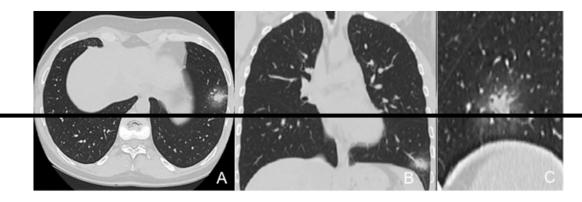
Axial-2D (A), coronal-2D (B) and sagittal-2D (C) chest CT images show a left lower lobe single rounded consolidation surrounded by well-defined groundglass opacity (halo sign). A distal pulmonary vein branch reaching the lesion is shown in B.
